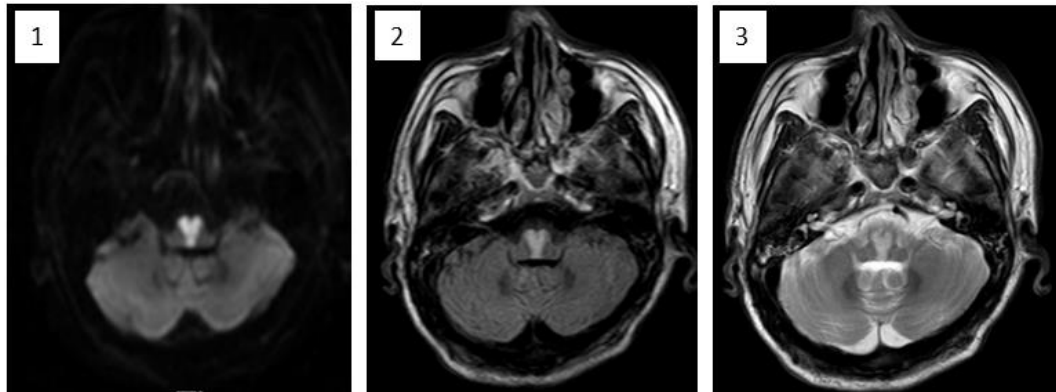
MRI head with bilateral medullary acute infarct in heart-shaped hyperintensity in the axial DWI (1), FLAIR section (2), and T2-Weighted (3).
